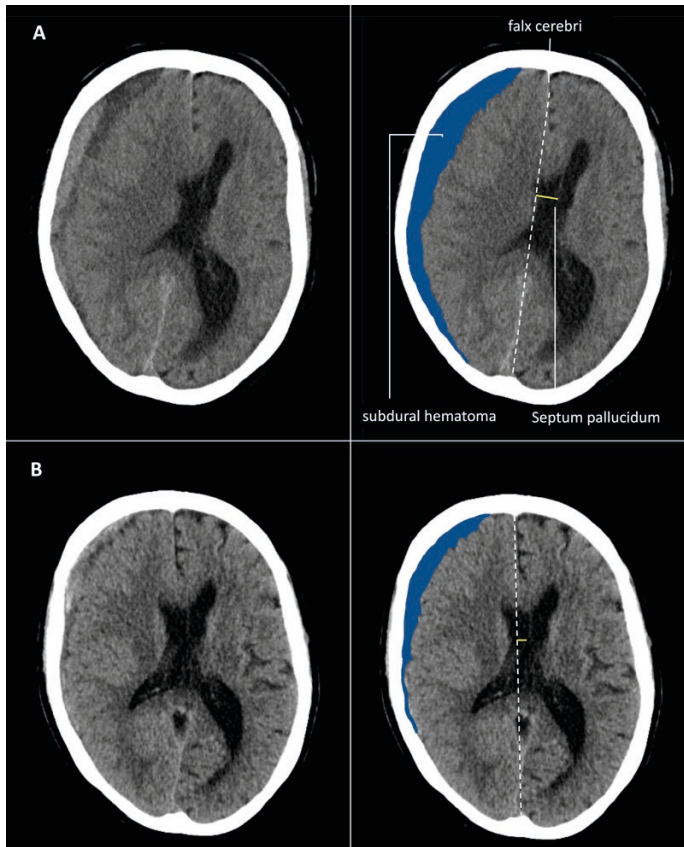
Patient B – CT-scan of chronic subdural hematoma at presentation (A), follow-up (B)
